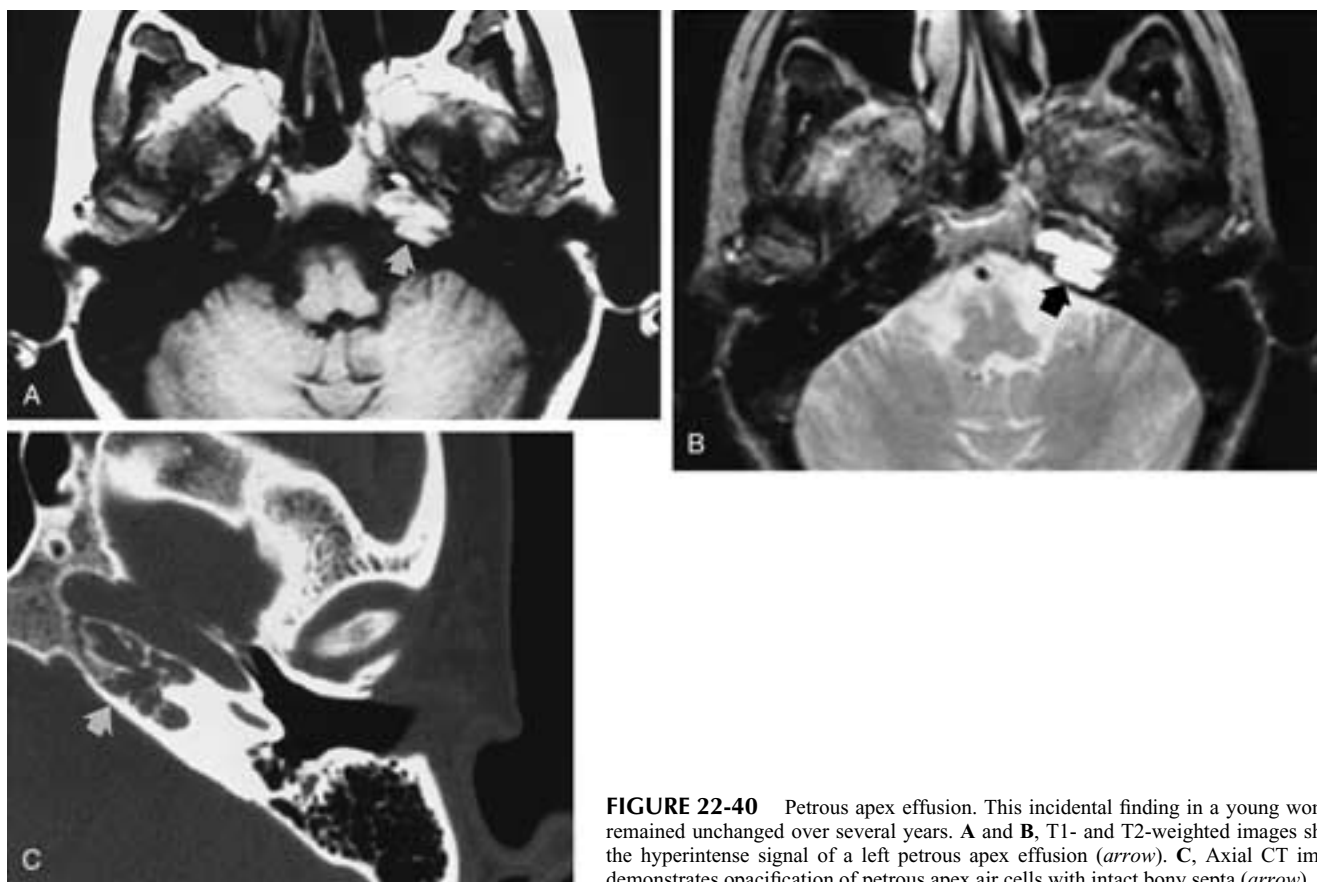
Petrous apex effusion. This incidental finding in a young woman remained unchanged over several years. A and B, T1- and T2-weighted images show the hyperintense signal of a left petrous apex effusion (*arrow*). C, Axial CT image demonstrates opacification of petrous apex air cells with intact bony septa (*arrow*).
